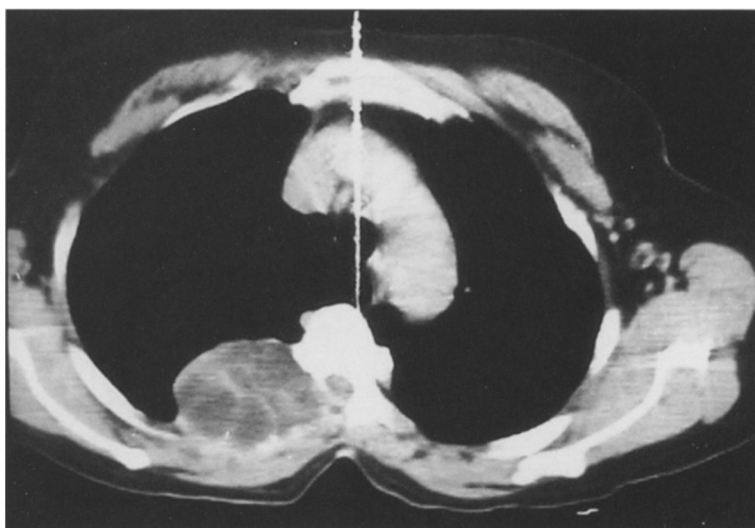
MRI scan of hydatid cysts in the right paravertebral region.
